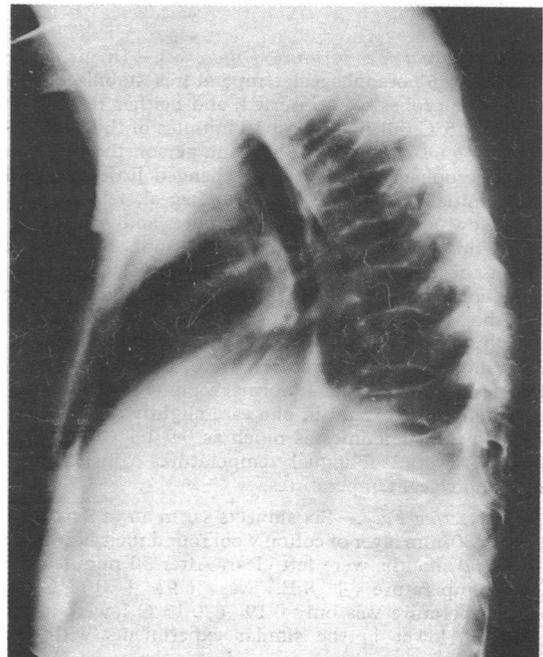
X-ray film taken June 1973 showing severe reduction in spinal bone density with vertebral collapse.
